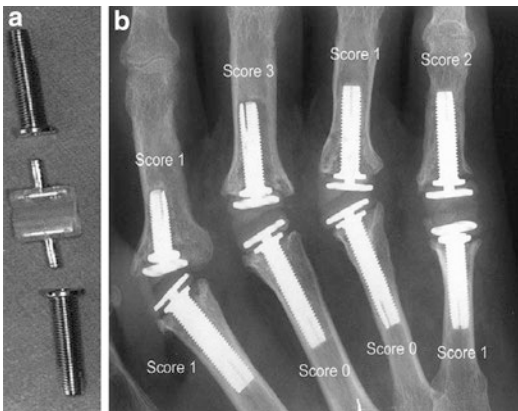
Osseointegration screw fixation. (a) The osteointegration technique for finger arthroplasty was introduced by Hagert and Brånemark for MP joint in 1986. Surgery was done in two stages, titanium screw fixture is placed in bone marrow cavities, and few weeks later, a flexible constrained silicone spacer was connected to the titanium fixtures. Lundborg later successfully used this technique in the PIP joint as a one-stage surgery. (b) Based on these measurements, the osseointegration of each fixture was assigned a score from 0 to 3. 0, Minimal or no change; 1, slight bone resorption under the joint connection, extending along less than half of the implant length; 2, moderate bone resorption with a narrow resorption zone extending more than half of the implant length or a wide irregular resorption zone extending at least half of the implant length; 3, obvious implant loosening, either with a wide irregular resorption zone extending around the implant or without implant subsidence or any implant subsidence of more than 1 mm on comparable radiographs with or without a narrow resorption zone around it. (Reprinted with permission from Möller et al. [62])
